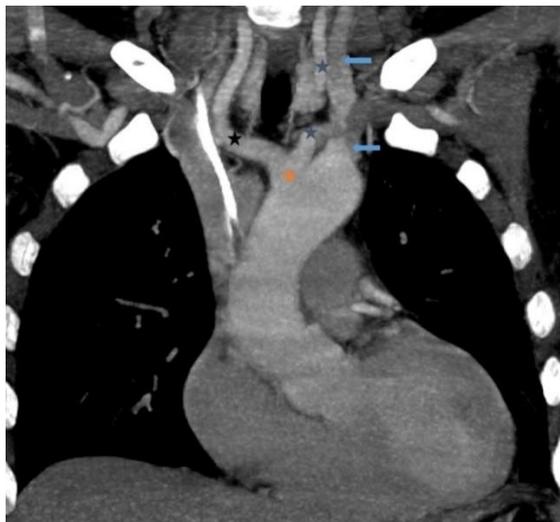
Chest CT, oblique coronal section with MIP: visualization of the aberrant right subclavian artery (blue arrow), bicarotid common trunk (orange star) subdividing into right common carotid artery (black star) and left (grey star)
